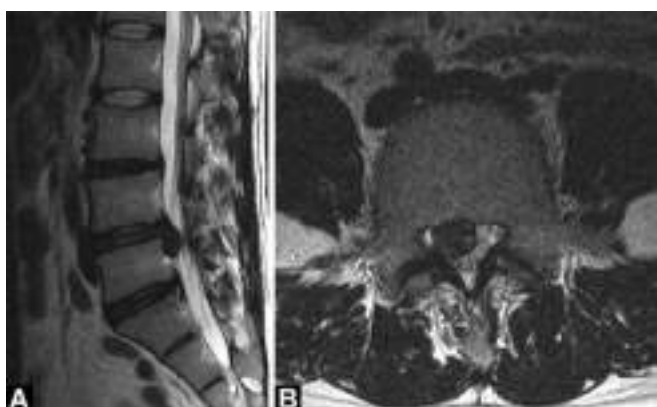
Sagittal (A) and axial (B) MRI images show disc bulging with annulus tear at L4-5 and skin entry point of PELA
